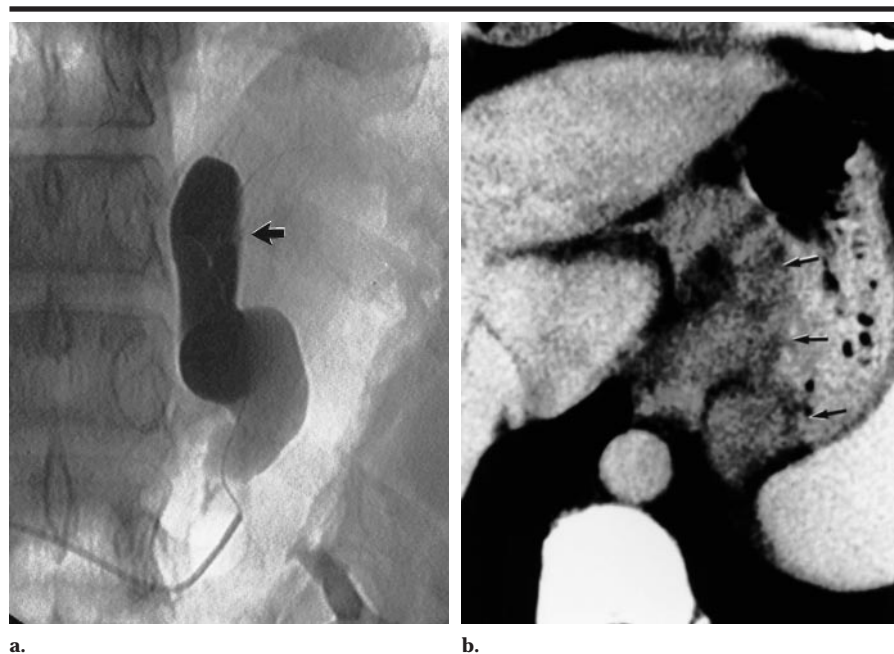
Grade 1 gastric varices and collateral veins in a 48-year-old man with a history of two episodes of esophageal variceal bleeding. (a) Left adrenal venogram shows large gastric fundal varices. Because no collateral veins were seen on the balloon-occluded left adrenal venogram, balloon-occluded retrograde transvenous obliteration was performed with 18 mL of the ethanolamine oleate-iopamidol mixture. The ethanolamine oleate-iopamidol mixture filled the gastric varices (arrow). (b) CT scan obtained 1 month after balloon-occluded retrograde transvenous obliteration shows gastric varices (arrows) with very low attenuation, suggesting complete coagulation.
